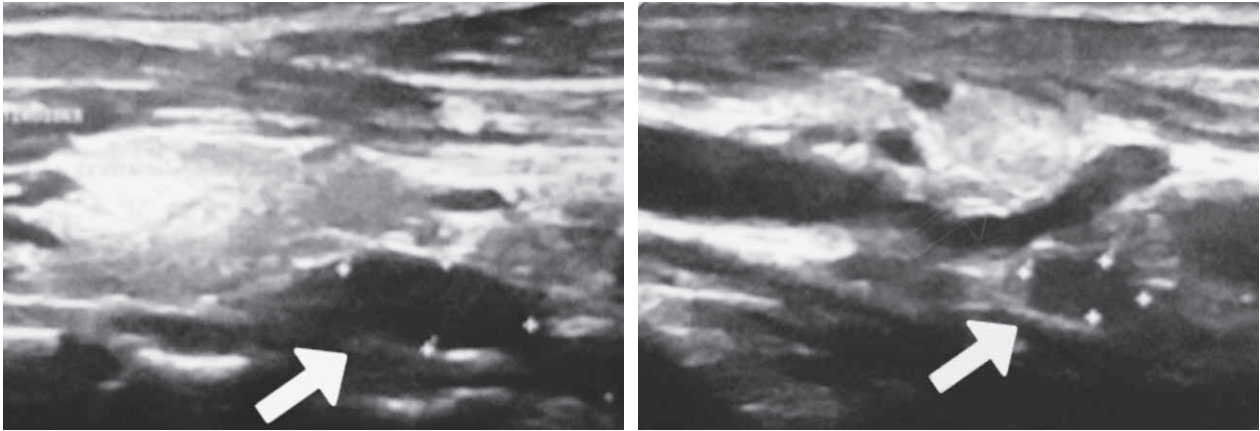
Cervical ultrasonography demonstrating hyperplastic parathyroid glands (arrow).
